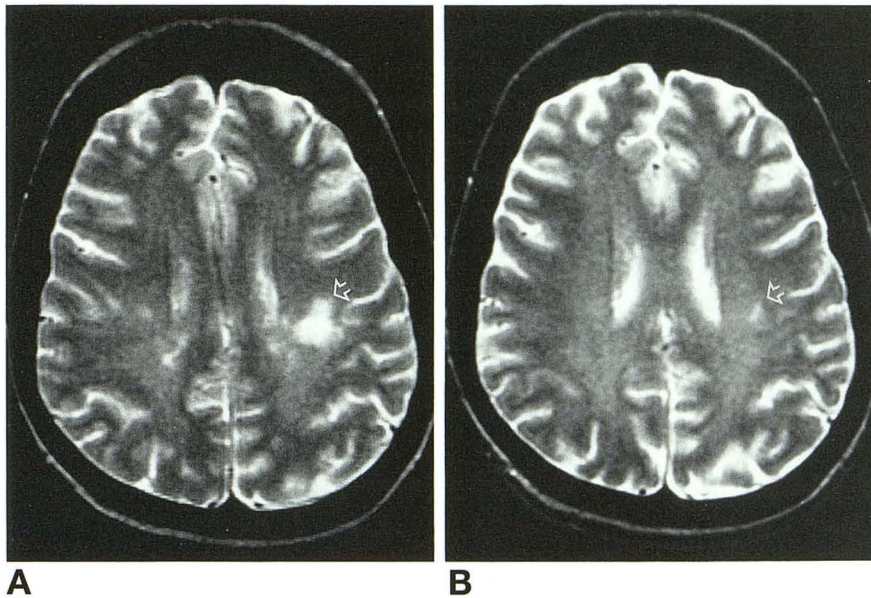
Patient 6, regression of white matter change. Axial T2-weighted acquisitions (2100/90) at and just above the lateral ventricles. At 9 months after bone marrow support, the white matter was normal.
